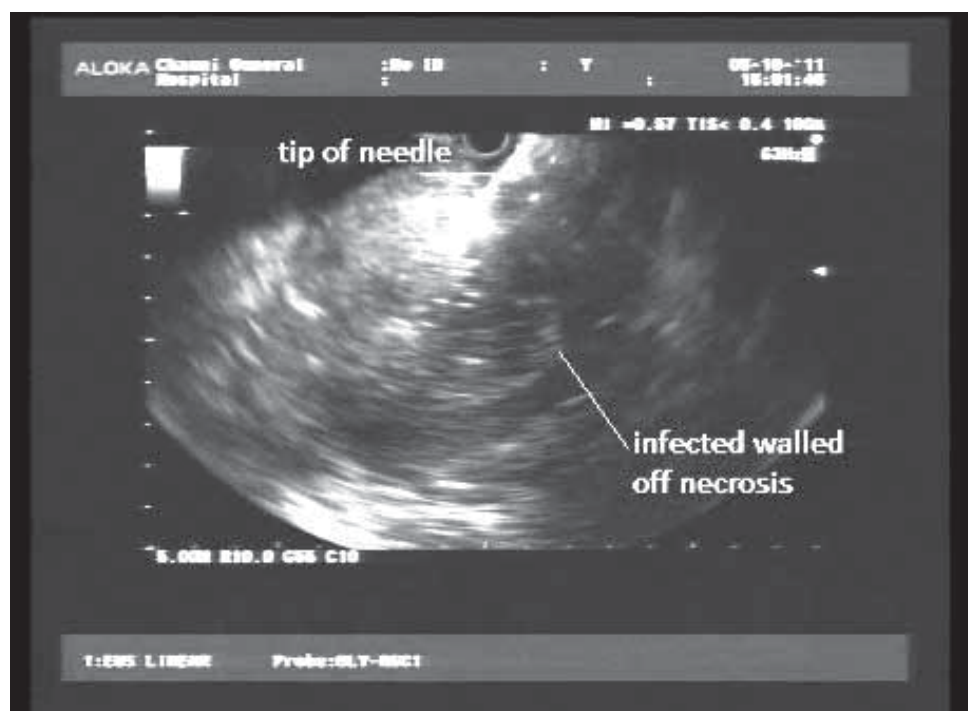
The walled-off pancreatic necrosis is punctured by a 19 gauge needle under endoscopic ultrasound guidance.
